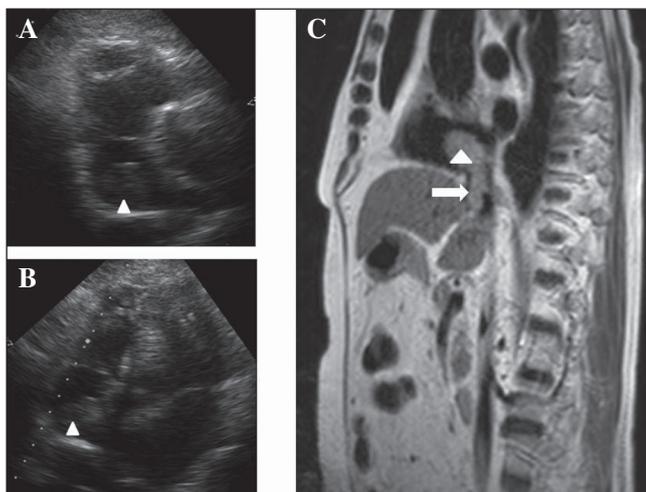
A. Parasternal short axis plane: heterogeneous mass in the RA (arrowhead). B. Apical four chamber: mass (arrowhead) that does not prolapse to the RV. C. Cardiac MRI: axial T2 cardiac section with a mass in the RA (arrowhead) coming from IVC (arrow).
